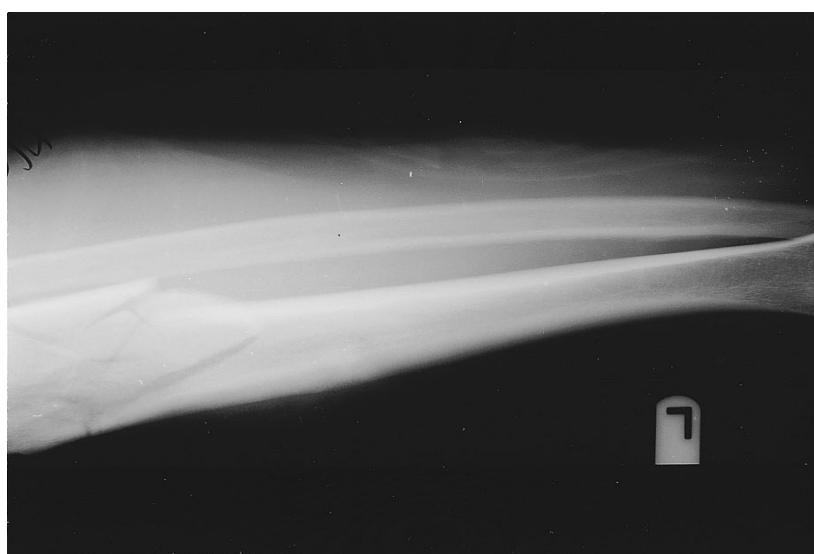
More radiographs from PWC File 10.
